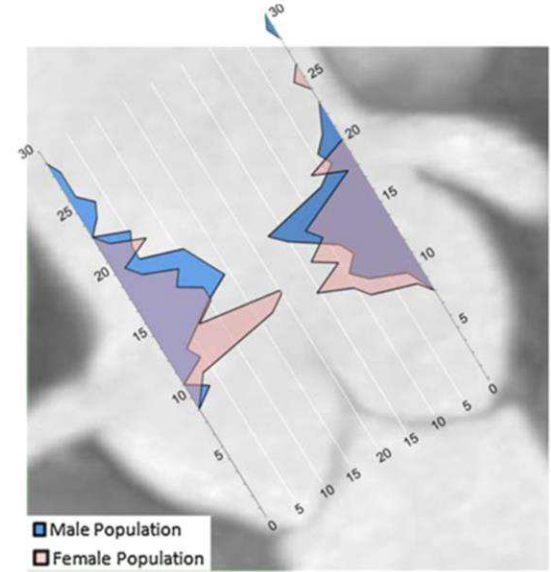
Coronary ostial distribution—Visual representation of the distribution of the locations of the right and left coronary ostia overlaid onto a CT image showing the corresponding anatomy of the aortic root. Note the lower location of the right coronary artery (RCA) ostium and wider variation as compared to the ostium of the left main artery (LMA)
